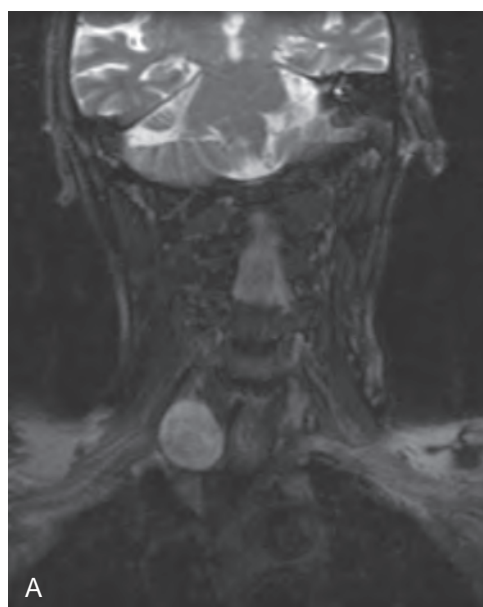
An axial T2-weighted magnetic resonance imaging (MRI) scan shows a heterogeneous high-signal mass in the left carotid space without flow voids (A). The mass enhances heterogeneously on a postcontrast T1-weighted MRI scan, which is the typical appearance of a schwannoma (B). (From Stambuk HE, Patel SG. *Imaging of the parapharyngeal space*. *Otolaryngol Clin North Am* 41[1]:77–101, vi, 2008.)
